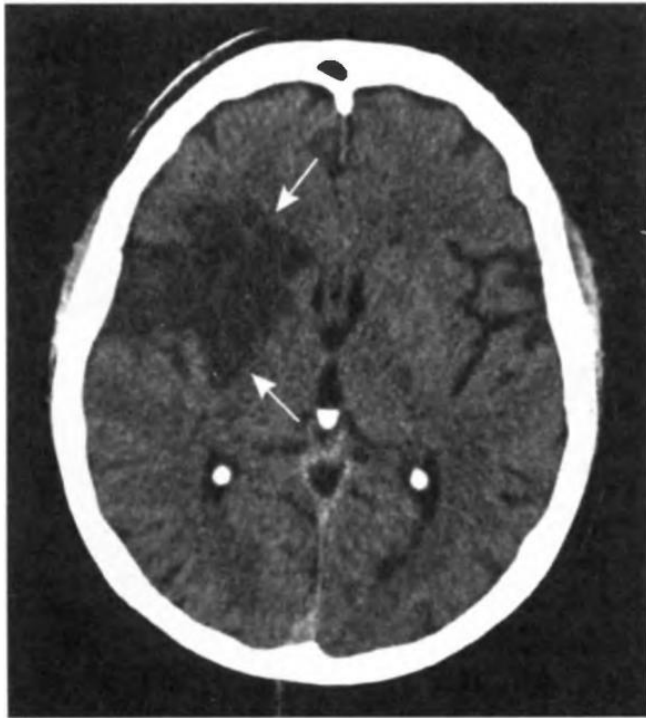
CT scan of the brain after 24 hours. The area of cytotoxic edema that formed at the site of the stroke (indicated by arrows).
